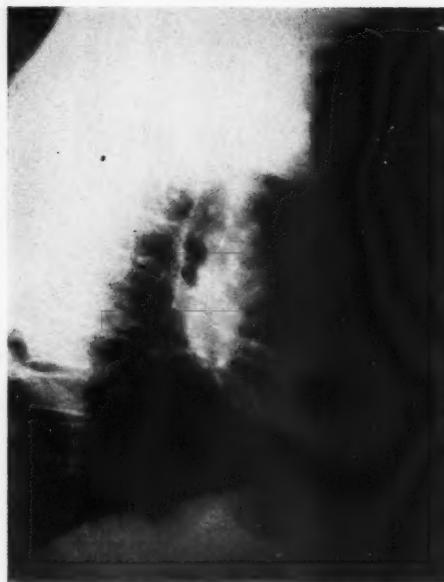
Case 4. X-ray (lateral) showed opacity in the hilus area prior to lung collapse.
